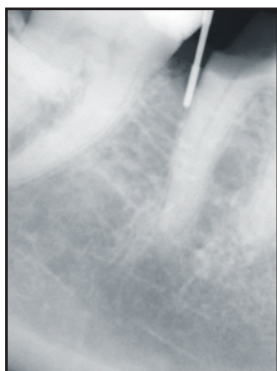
Postoperative radiograph demonstrates that, after closed crown lengthening, the measurement can be corrected to 3 mm.
